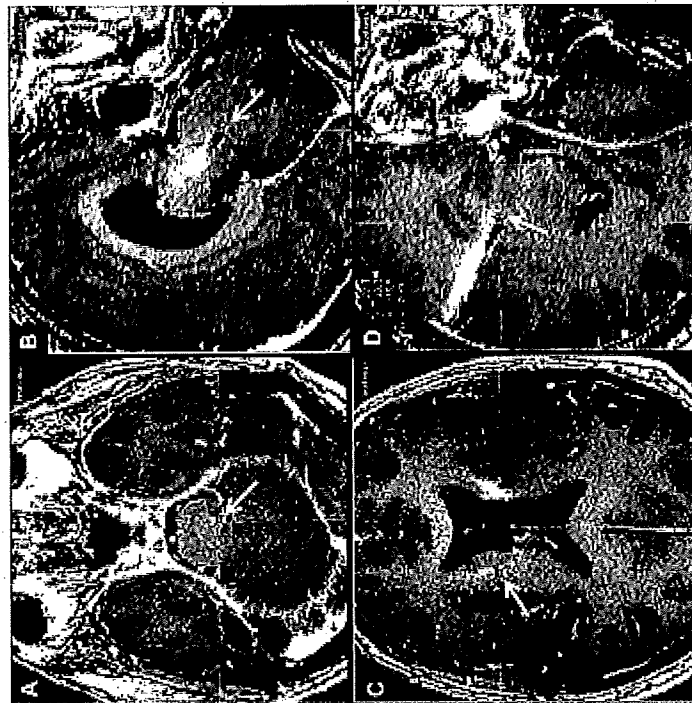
Lead misplacement. Arrows indicate the tip of DBS leads. (A) An axial slice (A) and a sagittal slice (B) of a T1 weighted magnetic resonance imaging (MRI) scan revealed the tip of the left DBS lead located too far posterior and deep for the subthalamic nucleus (STN). An axial slice (C) and a sagittal slice (D) of the same MRI scan revealed too shallow location of the left DBS lead.
